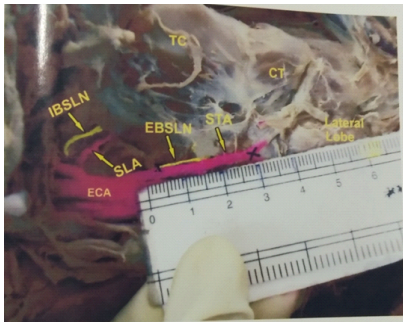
External branch of superior laryngeal nerve(EBSLN) crossing superior thyroid artery(STA) above 1cm from superior pole of thyroid gland-TYPE 1 of Cernea's classification. Upper limit of thyroid gland and the area of crossing over marked as (x).IBSLN=Internal Branch of Superior Laryngeal Nerve, TC=Thyroid cartilage, ECA= External Carotid Artery, CT=Cricothyroid muscle
